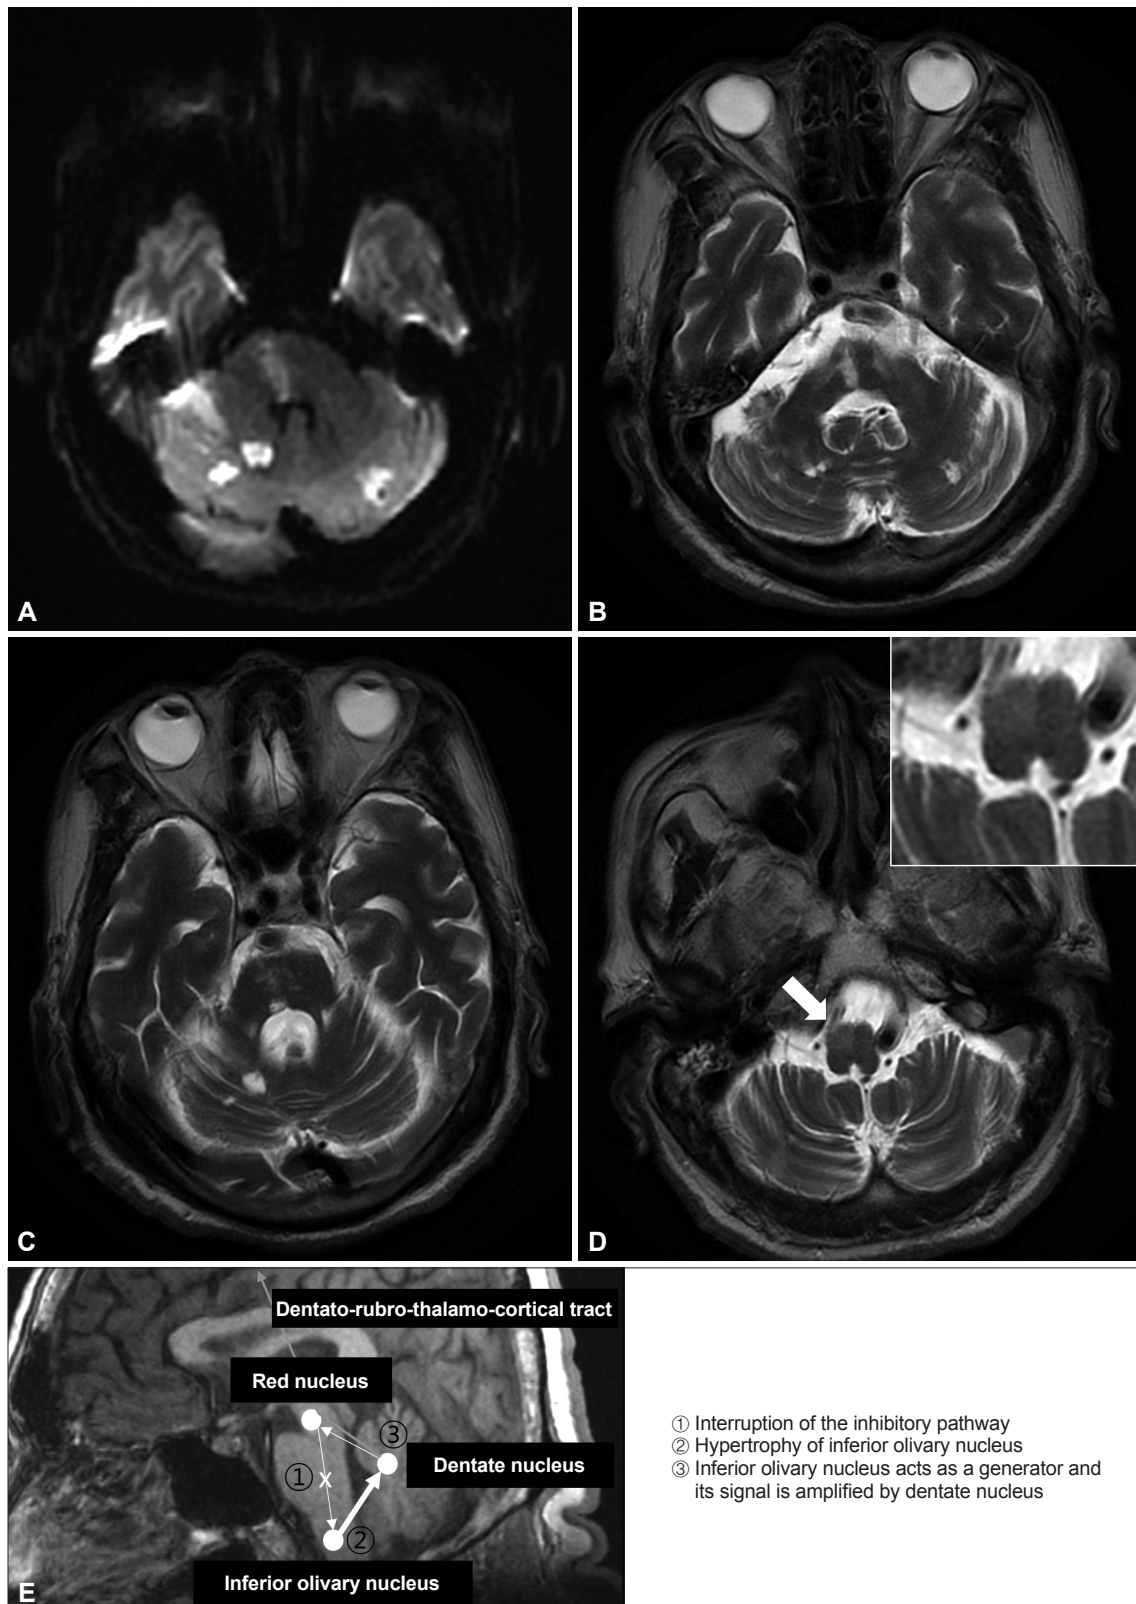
Brain magnetic resonance imaging of the patient. A: Diffusion-weighted image shows ischemic multiple posterior circulation stroke in both the cerebellum and right paramedian pons. T2-weighted images show old lesions due to previous ischemic strokes (B, C) and the hypertrophy of the right inferior olivary nucleus (arrow, D). E: The Guillain-Mollaret triangle is shown, formed by connections between the ipsilateral dentate nucleus, contralateral red nucleus, and contralateral inferior olivary nucleus.
